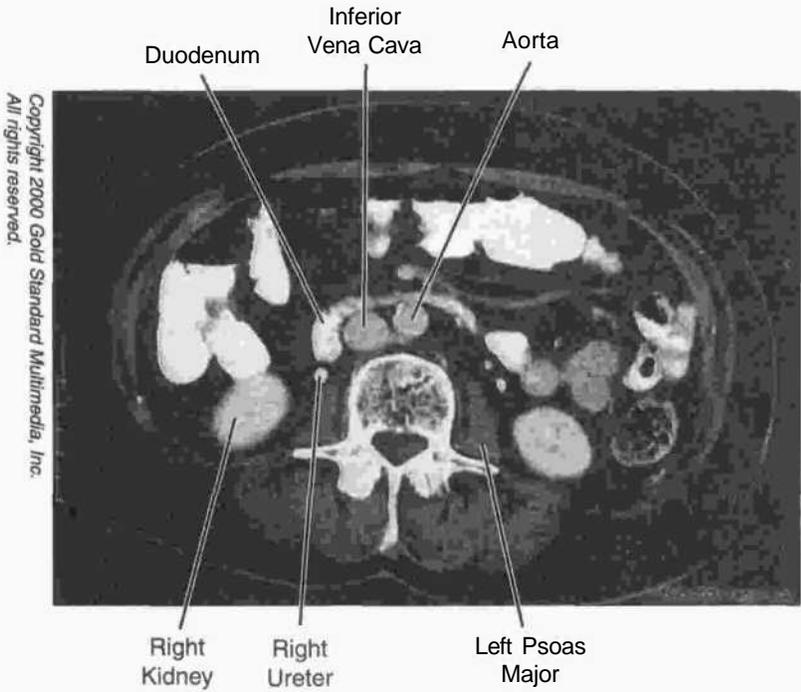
Abdomen: CT, L₃
